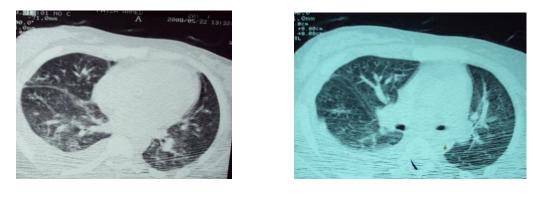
^{*}: Female patient ^{*} · y with SLE. Axial HRCT of the chest showing right plural effusion, thickened bronchila wall, thickened fissure
